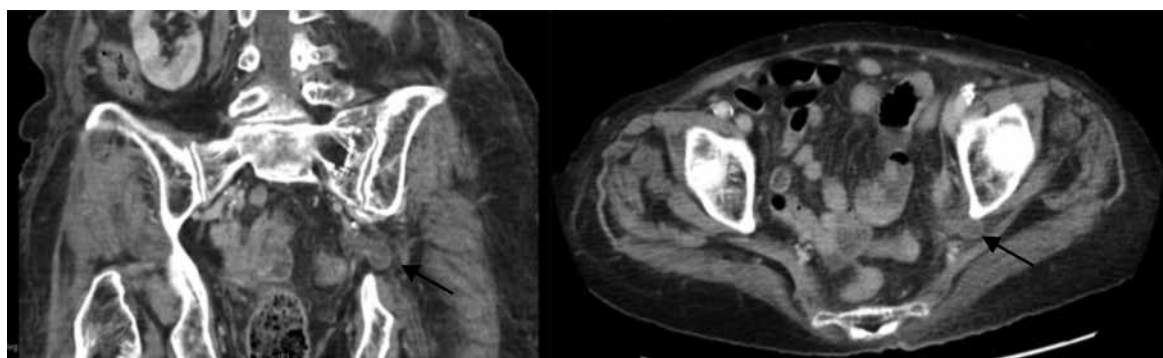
Coronal and axial computed tomography images showing left ureter with herniation into the left sciatic foramen (arrows)
